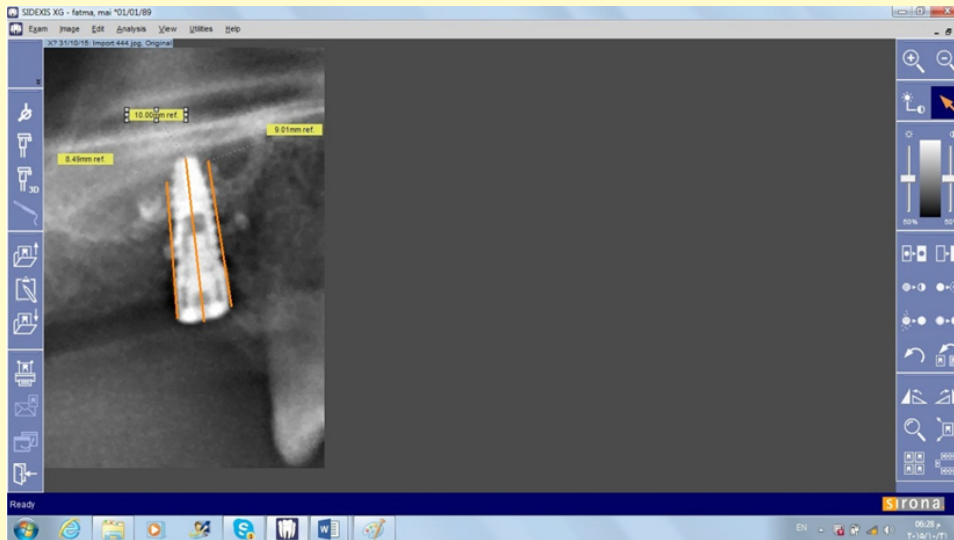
Radiographic picture showing the calculation of SBH2.
